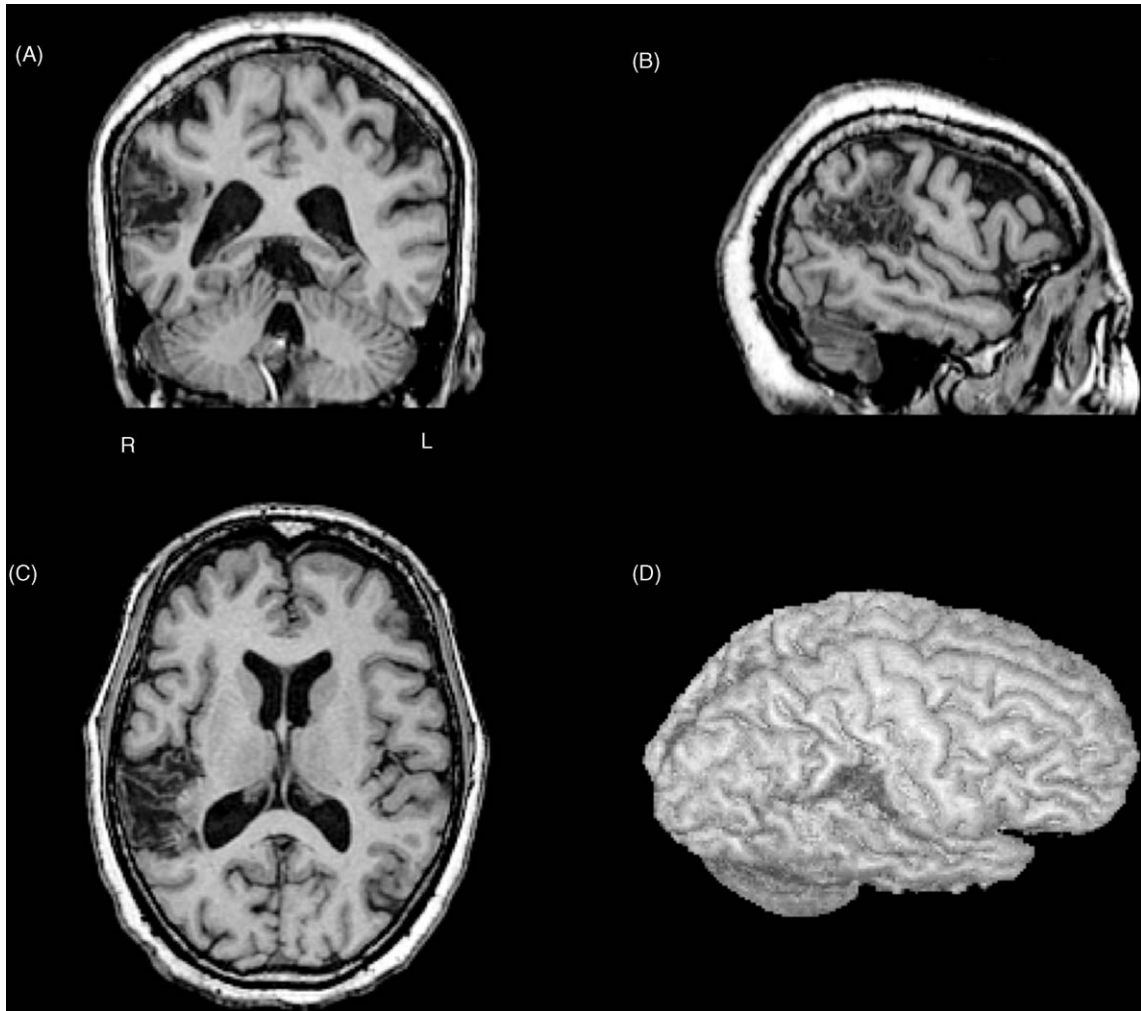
MRI of the brain. (A) Coronal section, (B) sagittal section, (C) transverse section through the lesion and (D) surface rendering of the MRI showing the lesion as a defect.
